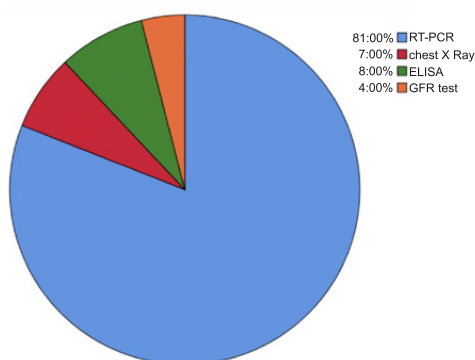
Pie-chart representing response for the awareness about the diagnostic tests, 81% of population answered as RT-PCR and 7% as chest x-ray and 8% as ELISA and 4% as GFR test.
